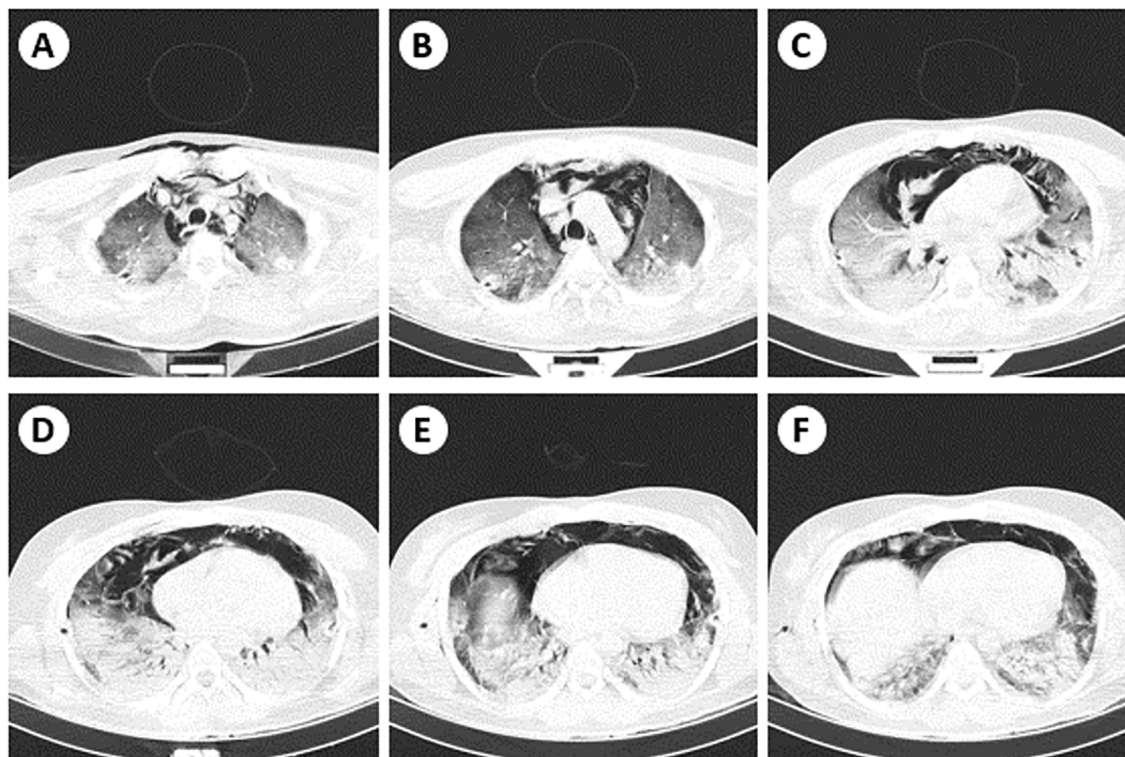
Chest CT scan of the patient showing ground glass opacities in apex (A, B), middle zone (C, D), and the base of both lungs (E, F).
